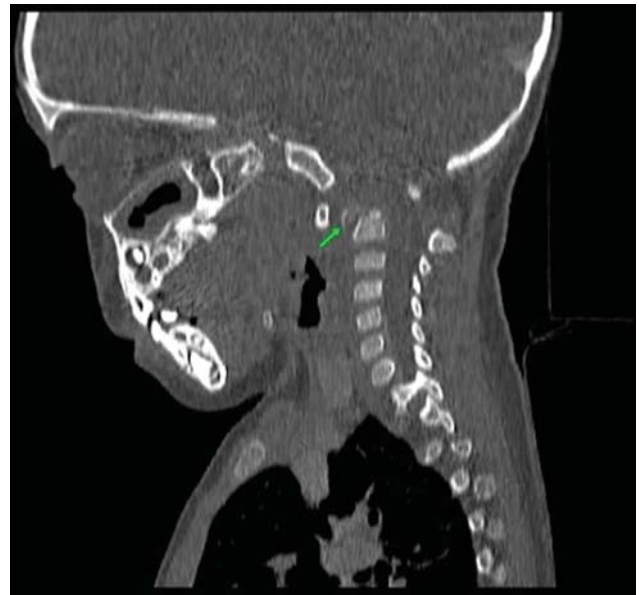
Contrast-enhanced computed tomography neck sagittal view; arrow showed increased in atlanto-dental interval with irregular lytic erosion over odontoid process and anterior vertebra body C2.
